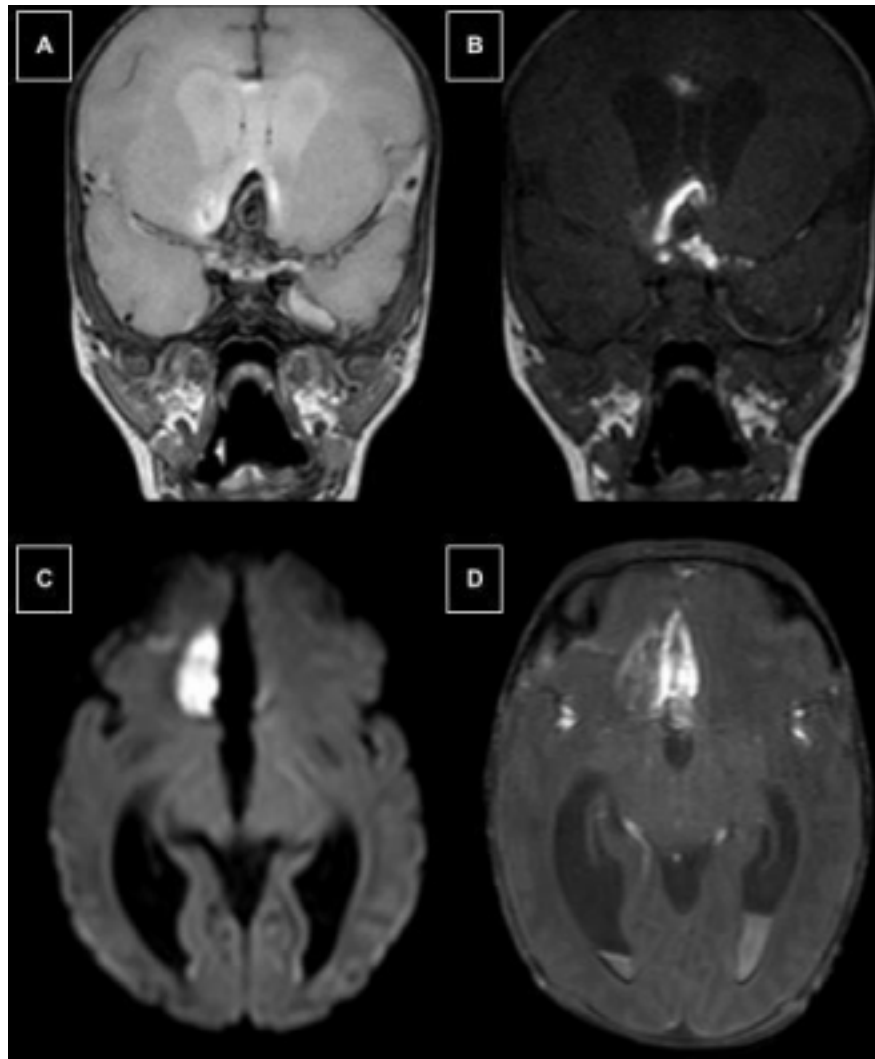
MRI of the brain. A) Coronal T2: subarachnoid hemorrhage in the antero-inferior interhemispheric region, with a slight mass effect on the medial aspect of both frontal lobes. B) Coronal T1: hyperintense signal of the subarachnoid hemorrhage, consistent with the subacute stage. C) DWI: restricted lesion in the right medial frontal lobe, compatible with acute ischemic stroke in the anterior cerebral artery territory. D) TOF: interhemispheric subarachnoid hemorrhage obscures the proper assessment of the anterior cerebral arteries.
